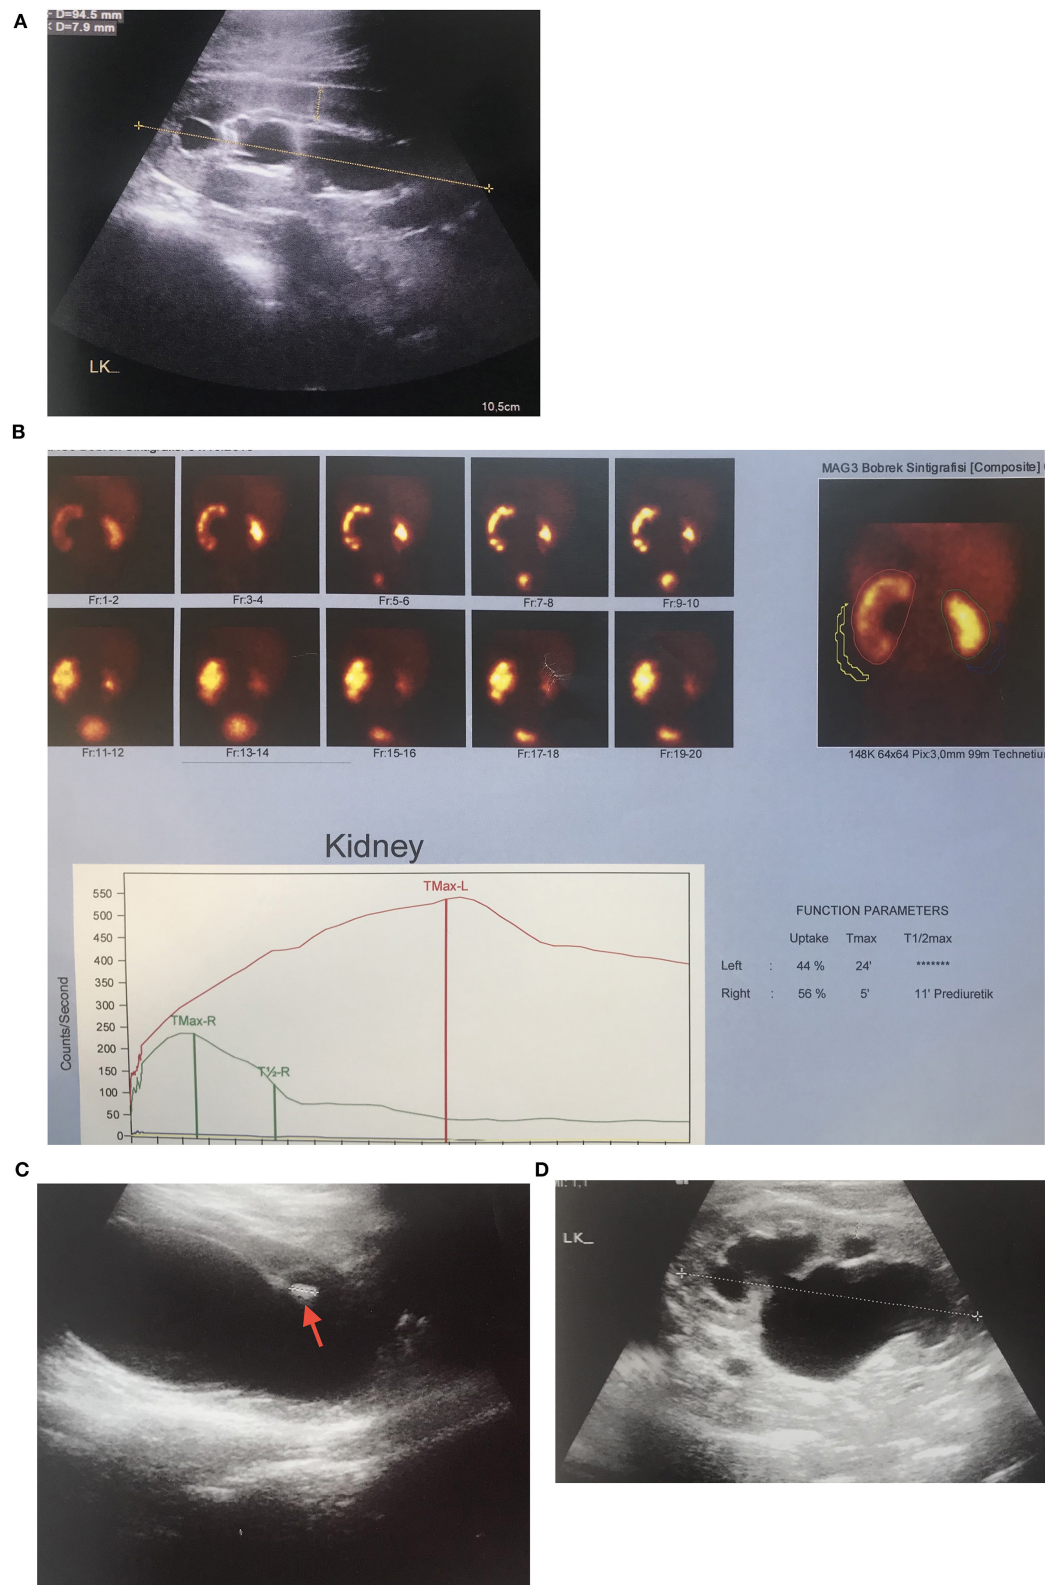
UPJHN in 3 months-old boy with prenatally detected left hydronephrosis (A) Severe hydronephrosis with 2.4 mm paranchymal thickness and 22 mm in AP diameter of pelvis renalis (B) Left obstructive hydronephrosis with 44% of differential function on MAG 3 scintigraphy (C) Mobile hyperechogenic particles in renal pelvis and calyces, hyperechogenicity in the lower calyces which are suggested urinary stone formation (D) Mild hydronephrosis with 8 mm paranchymal thickness and 16 mm in AP diameter of pelvis renalis in 9 years after left pyeloplasty.
